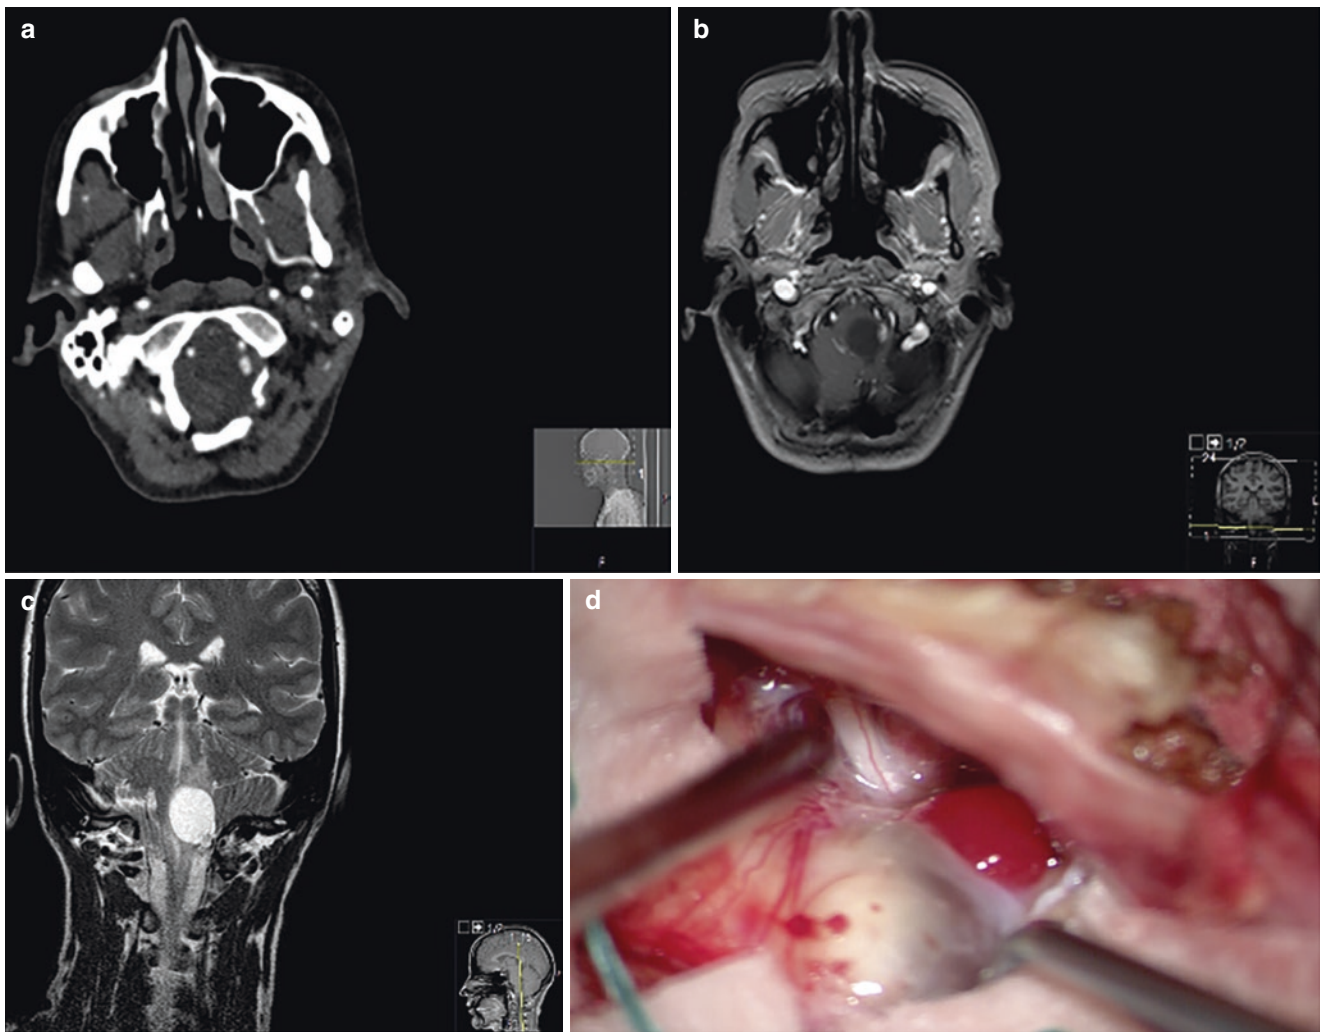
Pre-operative CT angiogram (a) and MRI (b: axial T1 gadolinium; c: coronal T2) with intraoperative views (d) of haemangioblastoma in close proximity to accessory nerve and vertebral artery
